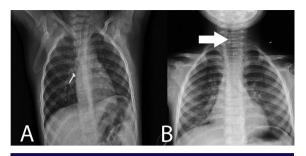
Radiopaque foreign body, chest X-ray (1A) showing a screw in the right bronchus. A radiopaque chicken bone located in the trachea (1B).
